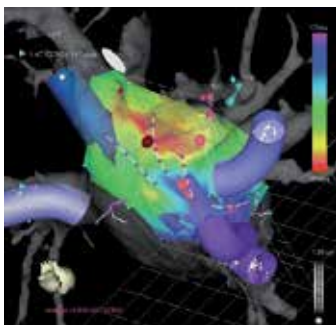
The CARTOMerge technology allows the electroanatomic map of the left atrium using CARTO to be integrated with the CT/MRI images using CARTOMerge module. The circles depict the corresponding points on the two maps. Image taken from Thornton et al., 2008. (doi: doi:10.1093/europace/eun080)
